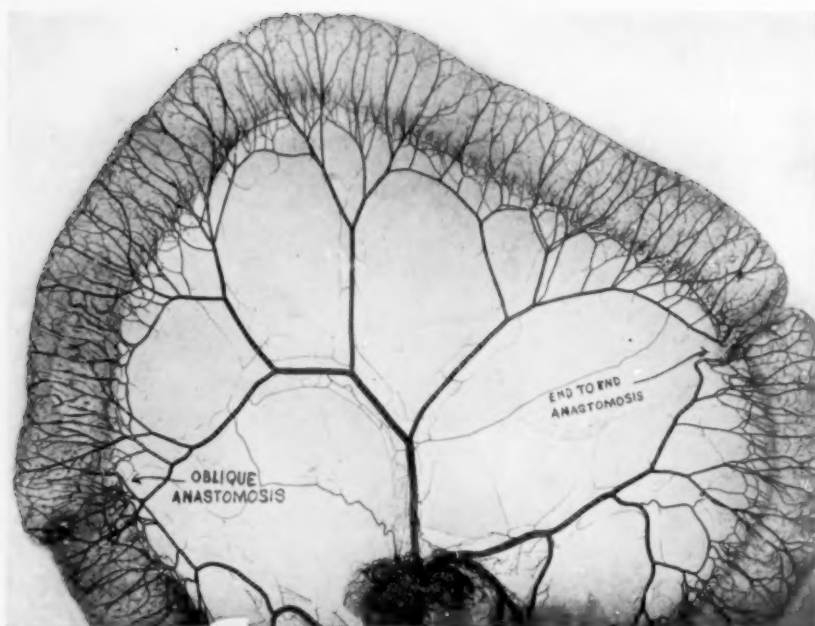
The X-ray picture of a loop of small intestine on which two anastomoses have been made, one by the end-to-end, the other by the oblique method is presented, in order to afford a comparison between the status of the blood circulation along the line of suture and especially at the mesenteric space (mesenteric angles). As shown in the other two pictures Figs. 3 and 18, the circulation of the intestine where an end-to-end anastomosis was performed is much poorer than the blood circulation of the portion where an oblique anastomosis has been done; compare specially the points marked with an arrow that indicates the status of the circulation at the mesenteric spaces, which is *nil* where an end-to-end anastomosis has been performed and very abundant where an oblique has been done.
